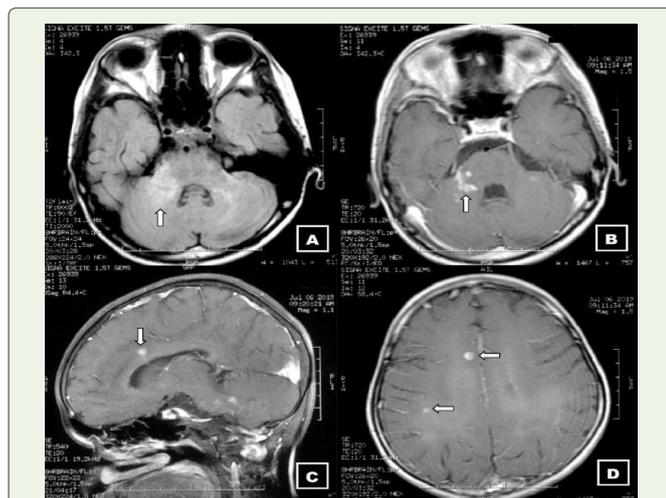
MRI Brain images of the child after the 3rd clinical relapse. A) Axial T2 FLAIR image at the level of the 4th ventricle shows a hyperintense lesion with thickening of the right middle cerebellar peduncle (arrow). Note the reduction in hyperintensity in the left middle cerebellar peduncle as seen in the previous scan (Figure 2C) B) Axial T1 T1 FS+C image showing the same lesion as in (A) with open ring pattern of enhancement, typical of demyelinating lesions (arrow). C) Sagittal T1 FS+C image showing enhancing small focus in the pericallosal white matter (arrow). D) Few enhancing small foci in the right centrum semiovale suggestive of acute demyelinating lesions (arrows).
